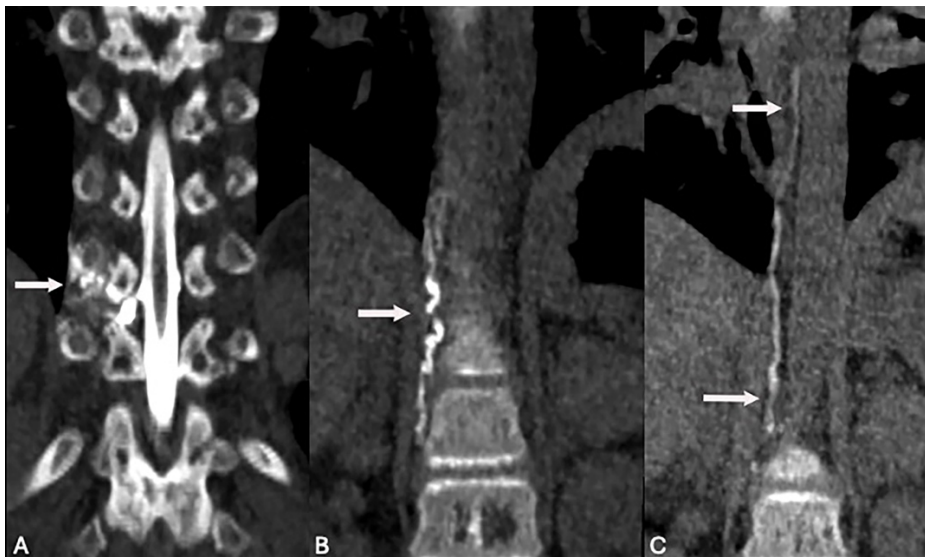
Patient 5, Spinal CSF-lymphatic malformation fistula in a 9-year-old female with a history of kaposiform lymphangiomatosis who had chronic headaches. Brain and spine MRI demonstrated severe brain sag, syrinx, and intraosseous spinal lymphatic malformations (not shown). *A-C*, Coronal images from a prone CT myelogram showed rapid egress of contrast from a right T10-T11 meningeal diverticulum to the paravertebral space (*A*, arrow). The thoracic duct also opacified to the level of the innominate vein (*B*, *C*, arrows), resembling a lymphangiogram. In retrospect, there was a lymphatic malformation identified in the right T10-T11 paravertebral space on MRI (not shown).
